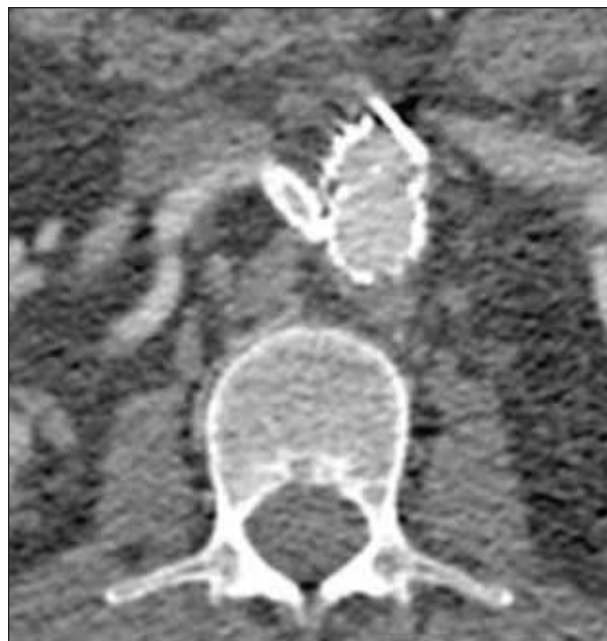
Postoperative computed tomographic angiogram showing no evidence of endoleak and demonstrating patency of the chimney graft.
